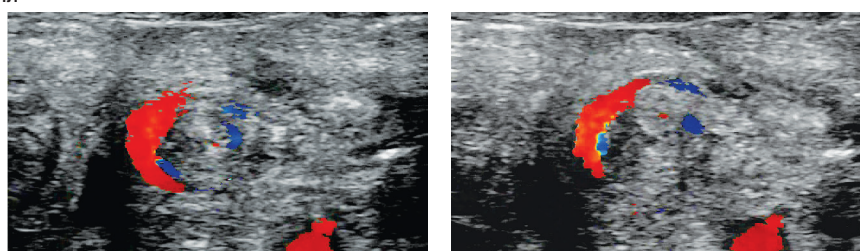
Whirlpool sign, or whirlpool symptom, detected in a newborn, color Doppler imaging
